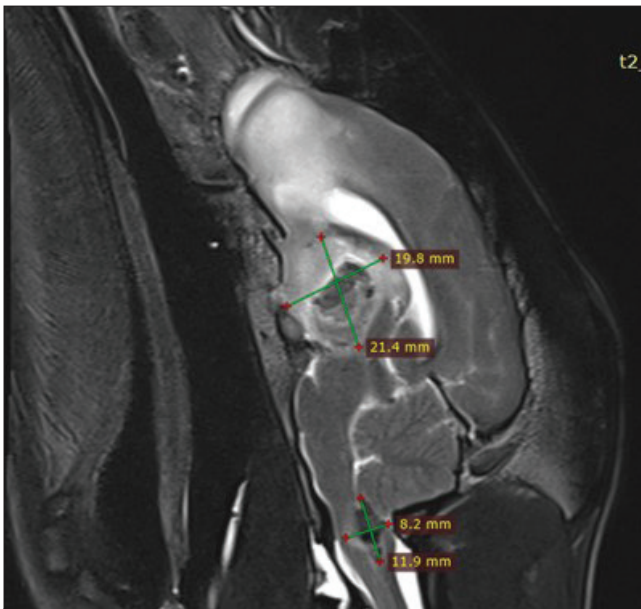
In the CMRI evaluation of the patient, on the T2-weighted sagittal plane, expansion of the mass in the suprasellar cistern, third ventricle and chiasma opticum levels of the brain to a size of 19.8 x 21.4 mm and the mass in the caudal cranial fossa adjacent to the medulla oblongata to a size of 8.2 x 11.9 mm
